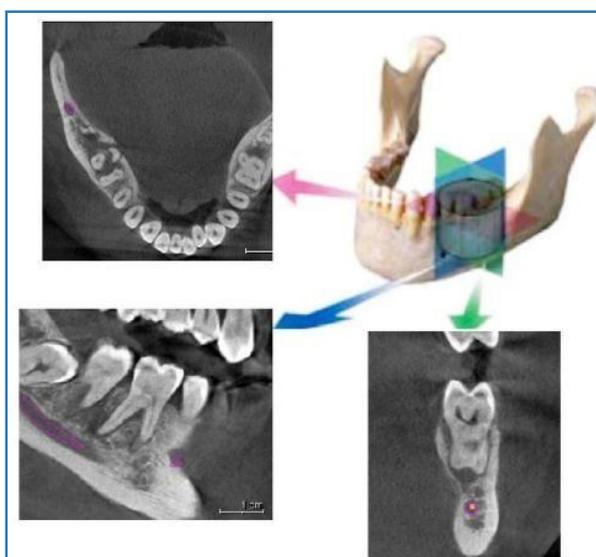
Standard Display modes of CBCT Volumetric data in the Axial, Sagittal and Coronal Plan
